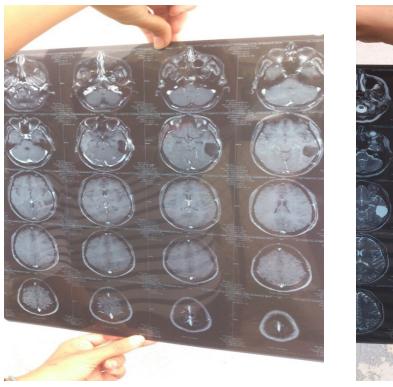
MRI scans before (A) and after (B) treatment
